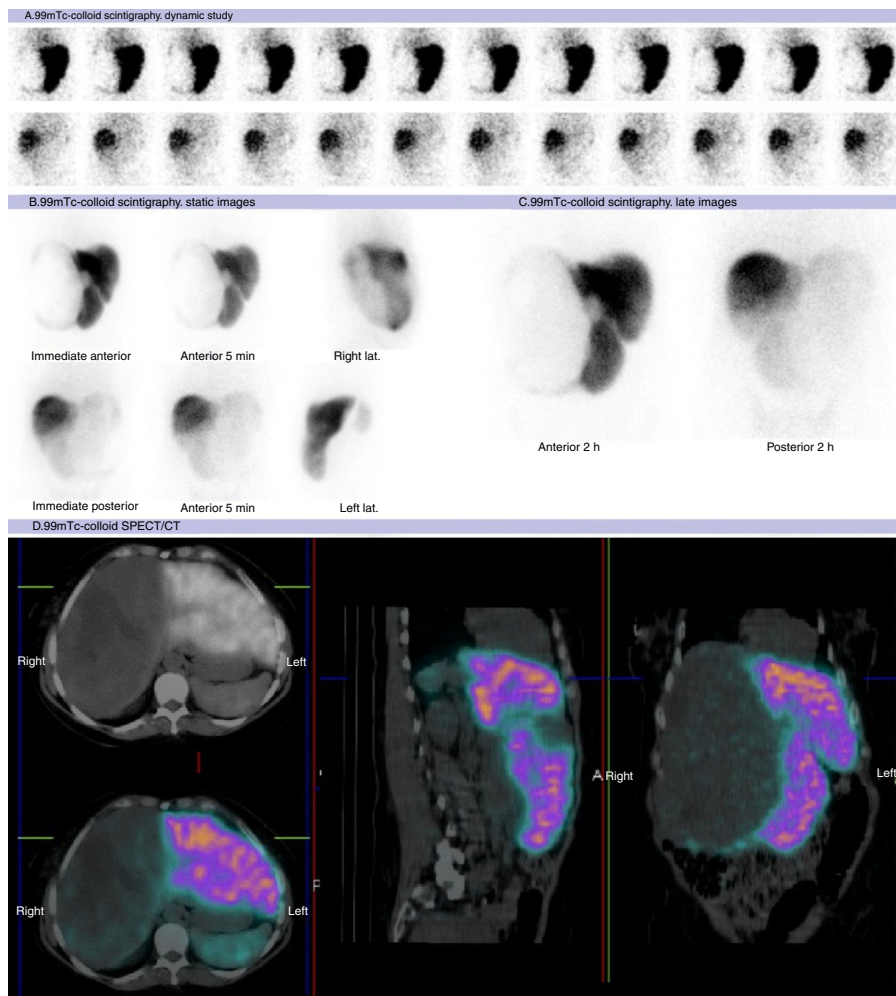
^{99m}Tc-phytate scintigraphy (A: dynamic study, B: static images, C: fused SPECT/CT images) corroborates the nature of the lesion due to the complete absence of metabolism with higher density areas within it corresponding to infarcts, as seen in SPECT/CT (D).
